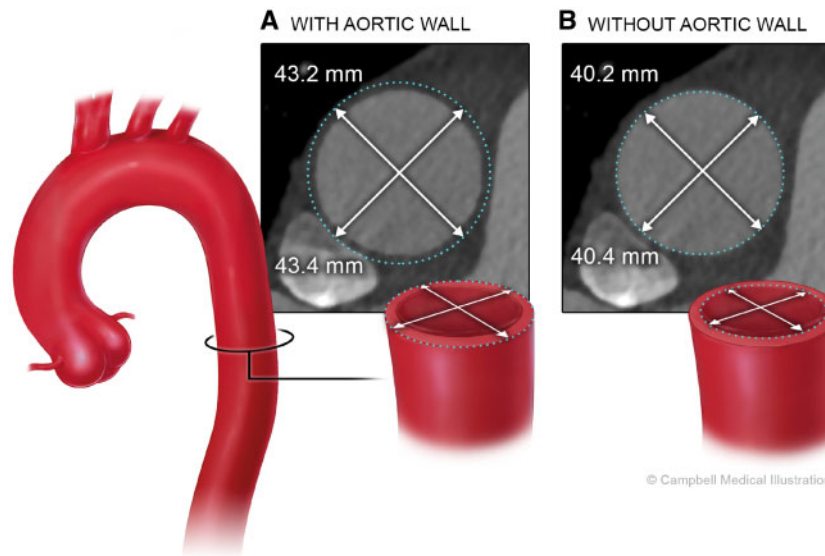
Measuring the maximal diameter (A) with or (B) without the aortic wall yields significantly different results. When using computed tomography imaging, it is recommended to give the external diameter, including the aortic wall.
